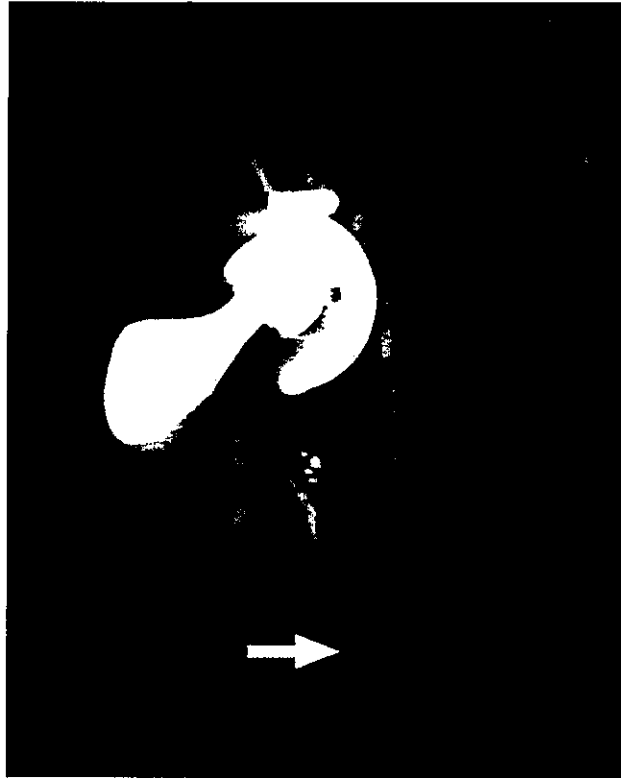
Two patients with osteolysis demonstrated by 3D CT imaging.
